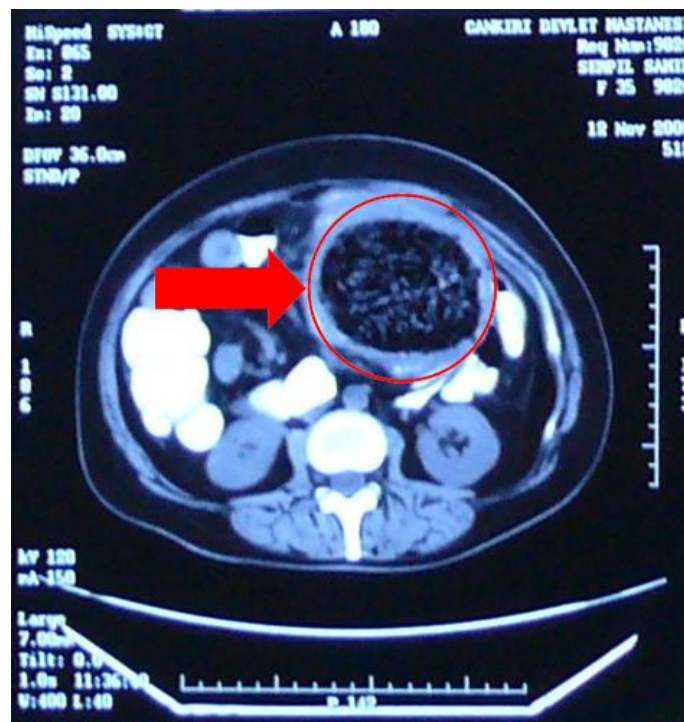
Abdominal CT scan revealed a round regularly organized intra-abdominal mass containing air bubbles localized to mid-section of the mass.
